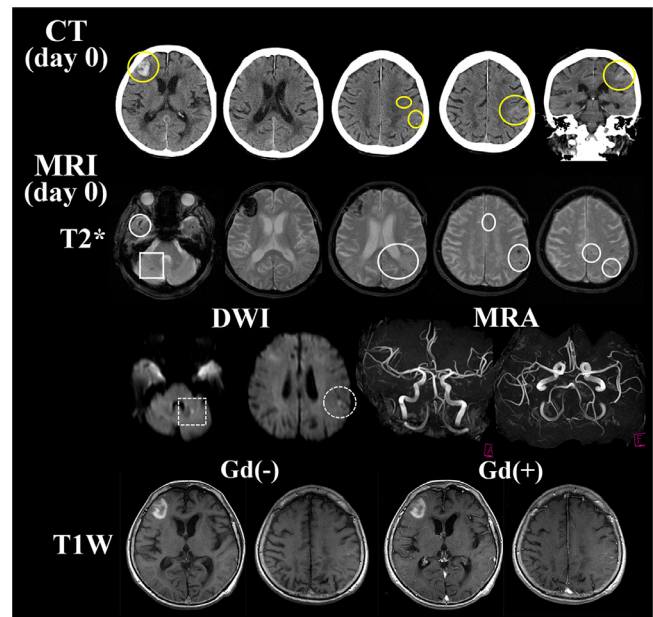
Computed tomography (CT) and magnetic resonance imaging (MRI) at admission. CT on admission showed multiple multi-type hemorrhagic lesions (yellow circles), which included subcortical hemorrhage in the right frontal lobe, microbleeds, and superficial cortical hemorrhage in the left hemisphere. T2*-weighted MRI demonstrated multiple microbleeds (white circles) including the right cerebellar hemisphere (white square) that were not identified on CT, which were suggestive of old microbleeds. Spotty high signals (white dotted circles) including the left cerebellar hemisphere (white dotted square) were also identified on diffusion-weighted imaging (DWI), which were suggestive of acute ischemia. No vascular abnormalities were identified on magnetic resonance angiography (MRA), and there were no enhanced abnormal lesions by gadolinium-dimeglumine (Gd) on T1-weighted imaging (T1W).
